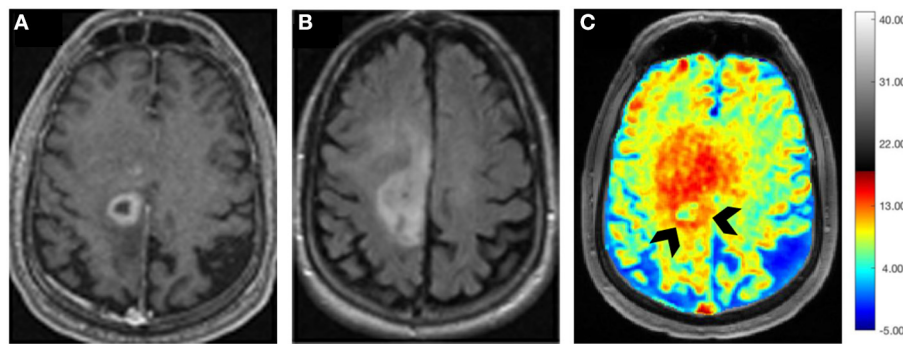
Axial postcontrast T₁ weighted image (A) demonstrating a ring-enhancing GBM with hypointense vasogenic edema in the left frontal lobe, which is visible as a hyperintense mass on the corresponding T₂-FLAIR image (B). B₀ and B₁ field in-homogeneity corrected Glu-CEST map (C) showing high glutamate signals from contrast-enhancing ring (arrowheads) and the surrounding brain regions beyond the contrast enhancement, suggesting infiltrative nature of this neoplasm.
